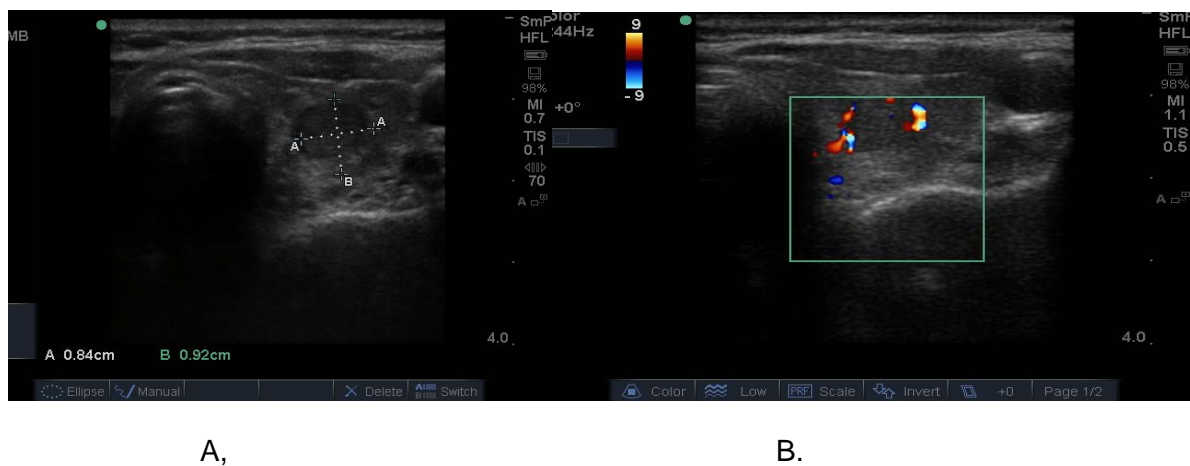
A small 8 mm benign nodule in the left thyroid lobe shown as an ultrasound image in (A) and with surrounding vascularity in (B)
